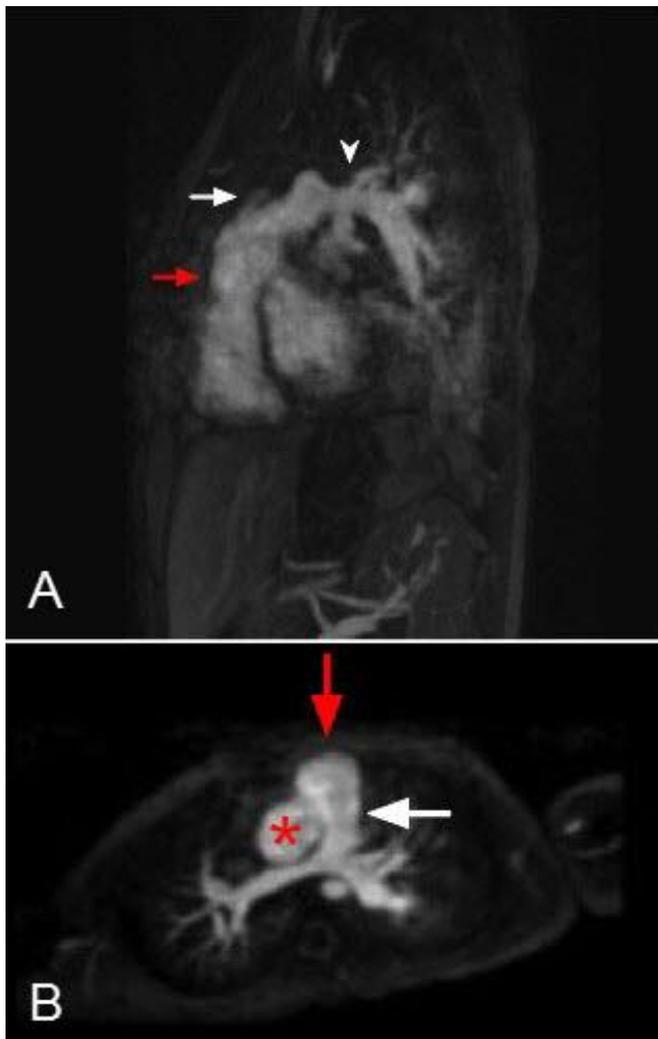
(left): 5-year-old female with truncus arteriosus repair and quadricuspid aortic valve. Oblique sagittal (A) and axial (B) thin maximum intensity projection (MIP) MR images obtained on a Siemens TimTrio 3.0T scanner using a 3D FLASH sequence (TR/TE/flip angle: 2.8ms/1.06ms/18°; matrix: 292 x 576; FoV: 281 x 500) following the intravenous administration of a single dose (5 mL) of Gd-based paramagnetic contrast agent (gadobenate dimeglumine), demonstrates a widely patent conduit (white arrow) between the RVOT (red arrow) and the main pulmonary artery (white arrowhead). (Red asterisk - aorta)
